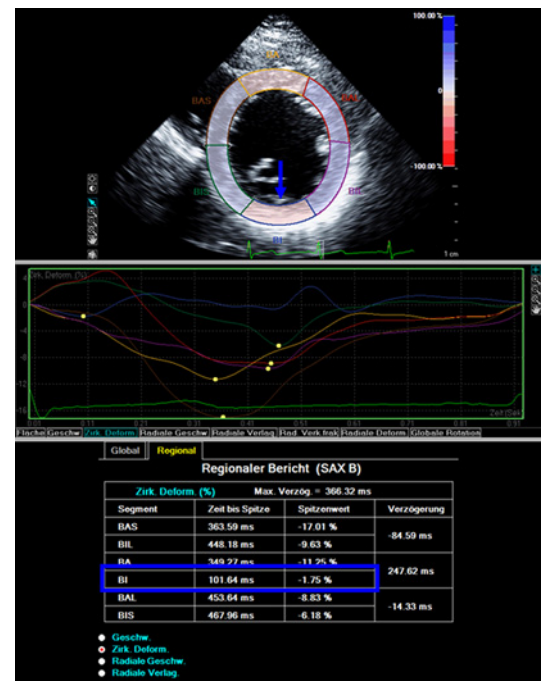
A three-beat cine loop selected from a two dimensional parasternal short-axis echocardiographic view using high frame rate harmonic imaging (iE33, Philips system). Endocardial and epicardial contours were manually traced with avoidance of papillary muscles and trabeculations (upper image). After definition of six in-lince segments, the peak circumferential strain was analysed for each segment using a two dimensional speckle tracking software (middle image; TMQ, QLab software, Philips systems). The calculated percentage values of peak circumferential strain for the respective segments are shown in the lower image. The inferolateral wall segment (indicated by the abbreviation BI and contoured in blue colour; marked by a blue arrow) demonstrated the lowest peak circumferential strain.
